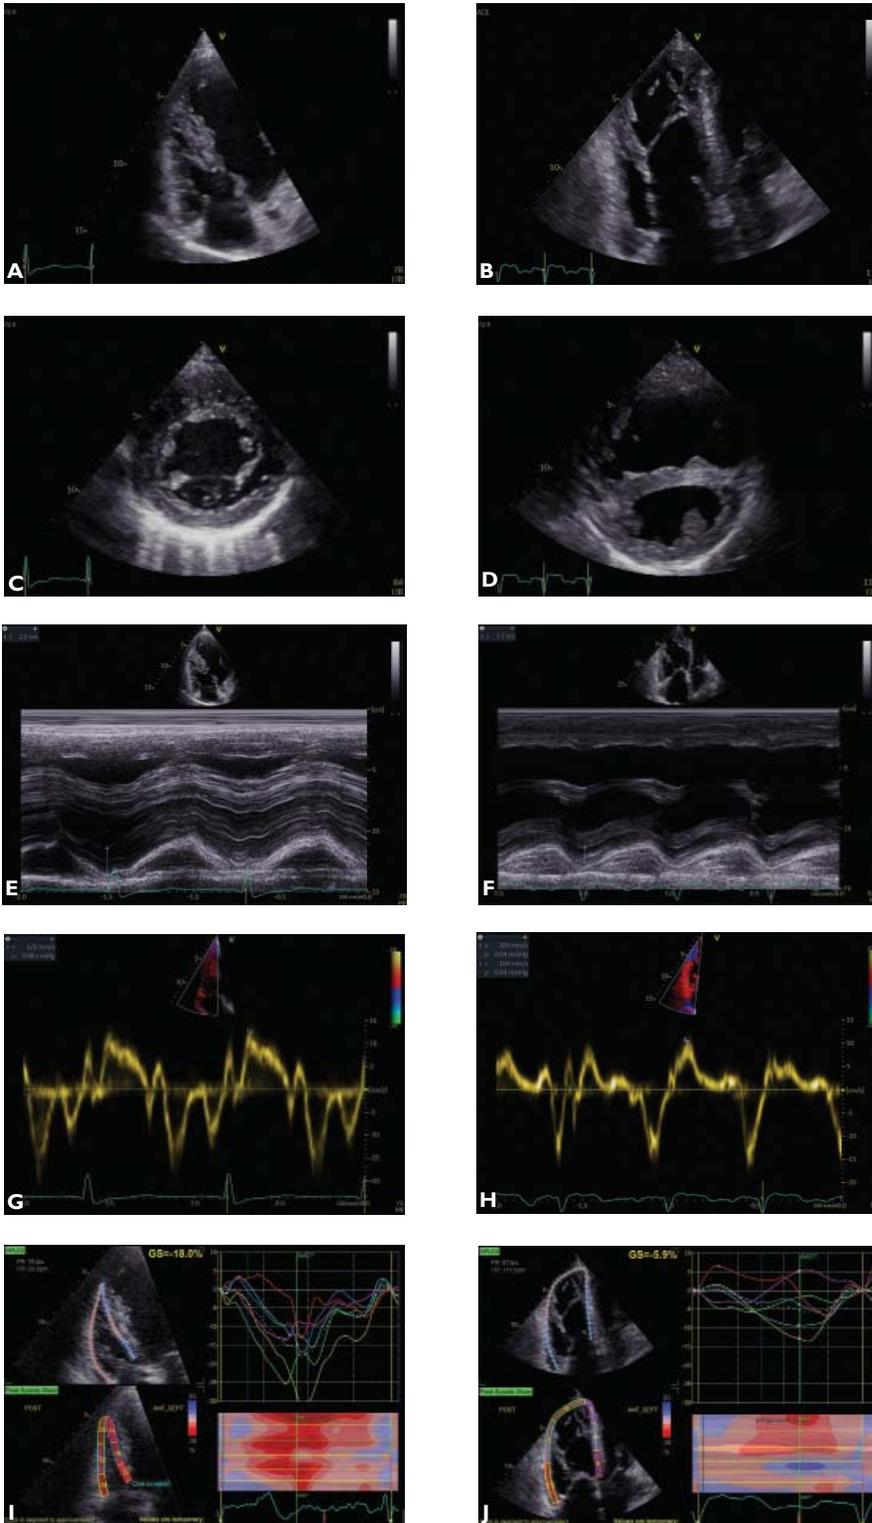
Comparison of echocardiographic characteristics in Eisenmenger syndrome secondary to a non-restrictive ventricular septal defect (left column) vs. non-restrictive atrial septal defect (right column) RV, right ventricle. IA. Transthoracic echocardiography, apical RV-focused view, 2D examination: adaptive RV hypertrophy with no dilation. IB. Transthoracic echocardiography, apical RV-focused view, 2D examination: maladaptive RV hypertrophy and significant dilation. IC. Transthoracic echocardiography, short-axis view, M-mode examination: adaptive RV hypertrophy with no dilation. ID. Transthoracic echocardiography, short-axis view, M-mode examination: maladaptive RV hypertrophy and significant dilation. IE. Transthoracic echocardiography, apical RV-focused view, M-mode examination: normal RV longitudinal function (TAPSE 21mm). IF. Transthoracic echocardiography, apical RV-focused view, M-mode examination: mild RV longitudinal dysfunction (TAPSE 17mm). IG. Transthoracic echocardiography, apical RV-focused view, TDI: normal RV longitudinal function (S'VD 12.6 cm/s). IH. Transthoracic echocardiography, apical RV-focused view, TDI: mild RV longitudinal dysfunction (S'VD 10.4 cm/s). II. Transthoracic 2D speckle-tracking echocardiography, apical RV-focused view: mildly reduced RV systolic function (6-segments longitudinal strain -18%). IJ. Transthoracic 2D speckle-tracking echocardiography, apical RV-focused view: severe RV systolic dysfunction (6-segments longitudinal strain -5.9%)
